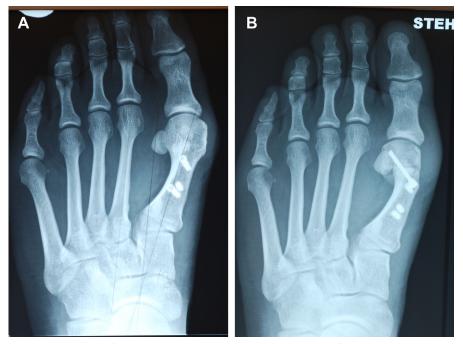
A 31-year-old female patient with hallux valgus recurrence following SCARF osteotomy. (*A*) Preoperative anteroposterior (AP) radiograph. (*B*) AP radiograph at follow-up following revision Chevron osteotomy.
